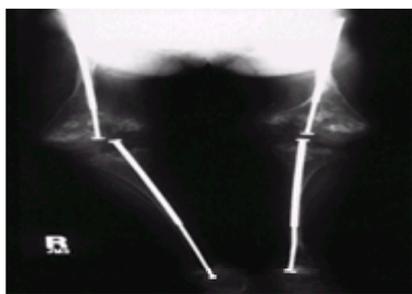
Radiograph of a patient with osteogenesis imperfecta, type III, after insertion of Bailey-Dubow rods.
